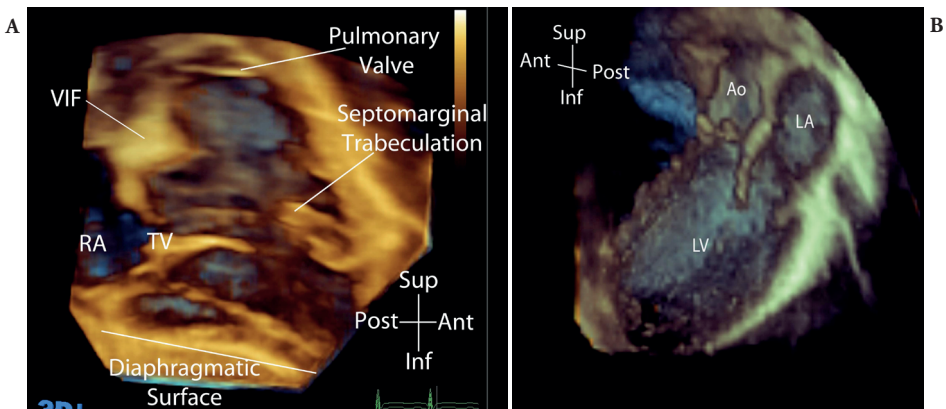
(A) Transthoracic rendered 3DE image of the right ventricular side of the normal ventricular septum. The free wall of the right ventricle has been cropped away in post-processing. The important landmarks can be readily identified including the tricuspid valve (TV), ventriculo-infundibular fold (IVF) and septomarginal trabeculation (septal band). This type of view can be used to project all types of ventricular septal defects. (B) Left side of the normal ventricular septum. A full-volume 3DE dataset was obtained by transthoracic 3DE in a parasternal long-axis view. The free wall of the left ventricle has been cropped away so that the ventricular septum can be directly visualised from the LV cavity. The smooth wall of the left ventricle can be appreciated.
